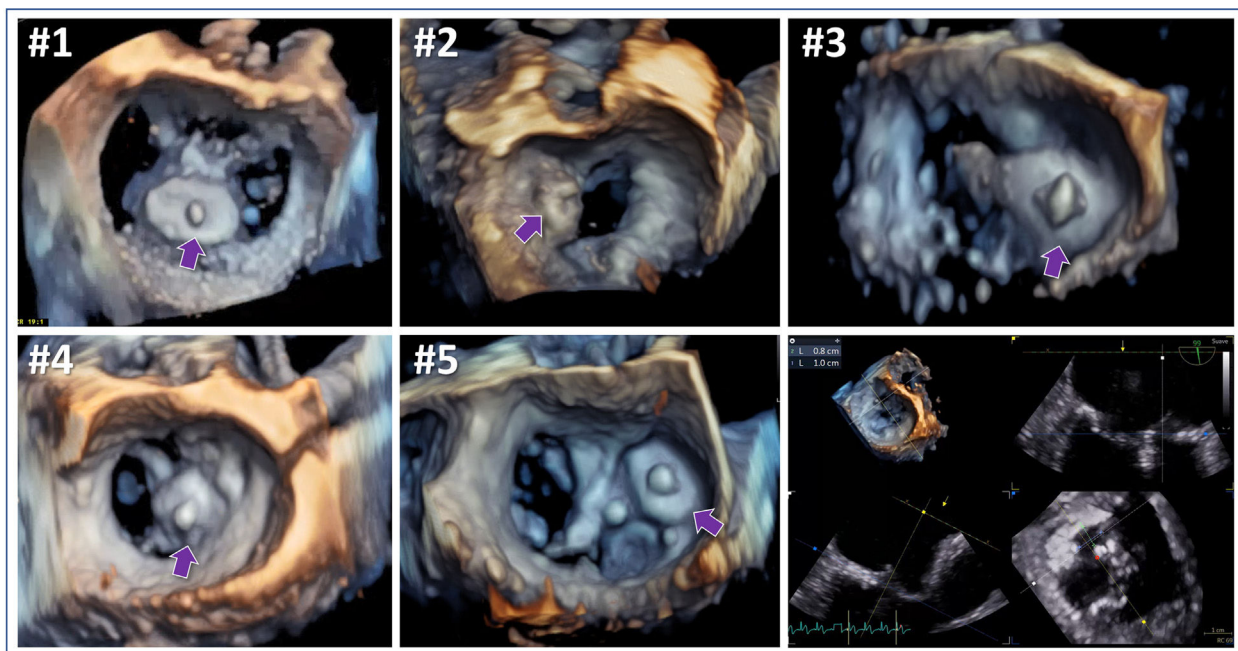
Three dimensional (3D) echocardiographic images of the mitral valve of the patients (#1 to #5) after AVP III implantation. Bottom right panel shows 3D measurements of the orifice to treat patient #2. Purple arrows point to the AVP III device. Pre- and postinterventional echocardiographic videos of patient #1 (video 1A-D of the supplementary data) and #2 (video 2A-D of the supplementary data) are available.
